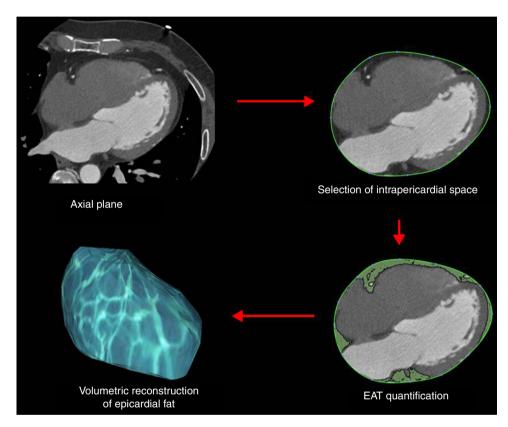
Process of EAT quantification by cardiac computed tomography (CT).
